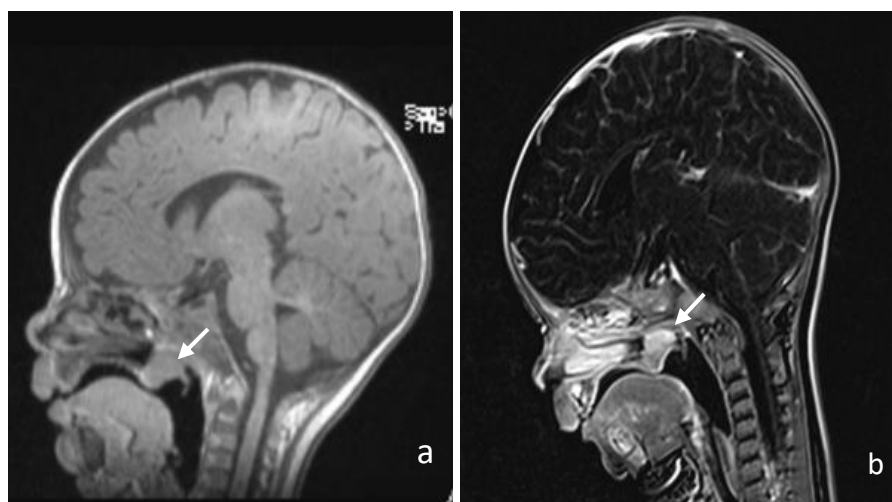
a) CT scan of the head and b) MRI of the brain with enhancement in the sagittal projection. The arrow shows nasopharyngeal neoplasm.
